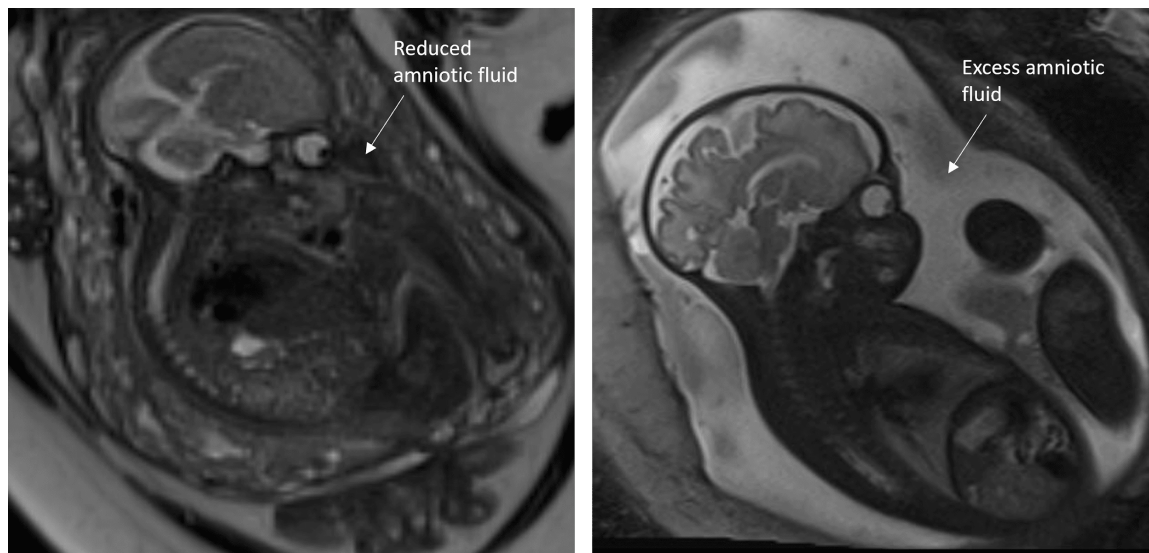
T2 HASTE Sagittal MRI image of oligohydramnios in 22+5 week fetus (left) and T2 HASTE Sagittal MRI image of polyhydramnios in 34+0 fetus (right)
